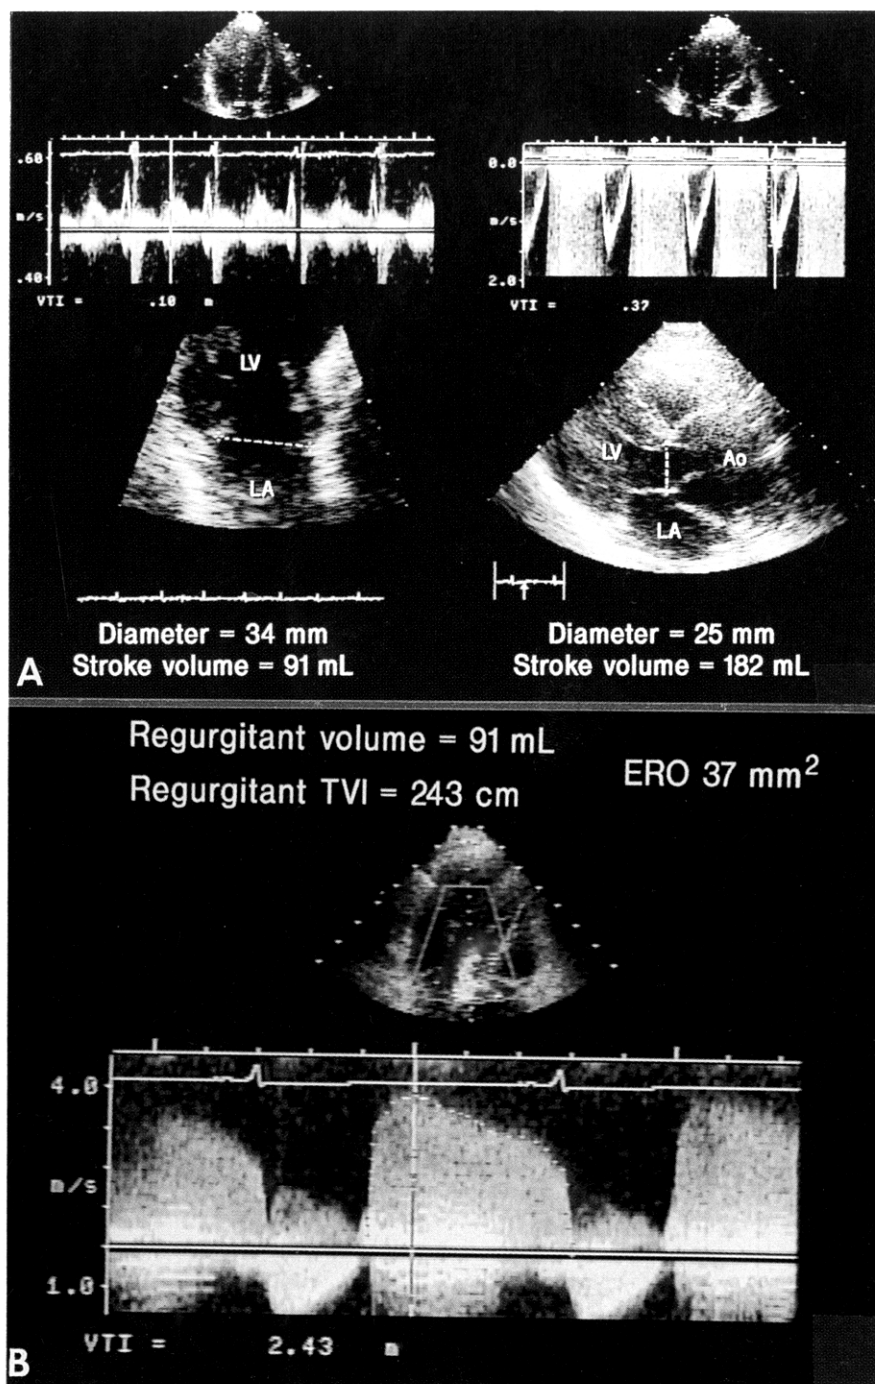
Example of calculation of effective regurgitant orifice in a patient with aortic regurgitation. A, Calculation of regurgitant volume with pulsed wave Doppler two-dimensional echocardiography. Left, Mitral measurement (34-mm diameter, 91-ml stroke volume). Right, Aortic measurement (25-mm diameter, 182-ml stroke volume). Abbreviations as in Figure 1. B, Continuous wave Doppler signal of aortic regurgitation. Outline of continuous wave Doppler signal is traced, and regurgitant time-velocity integral (VTI) is obtained. Effective regurgitant orifice = 37 mm²; regurgitant volume = 91 ml; regurgitant time-velocity integral = 243 cm.
